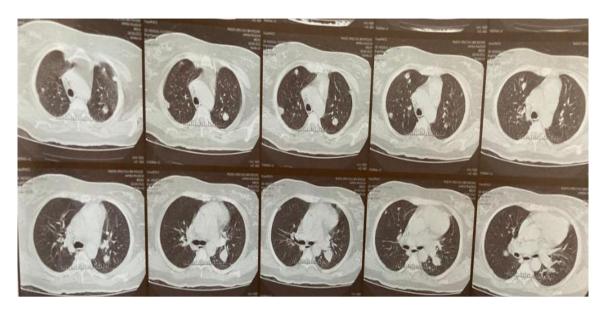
Angio CT-scan: Parenchymal view: Absence of pulmonary embolism
